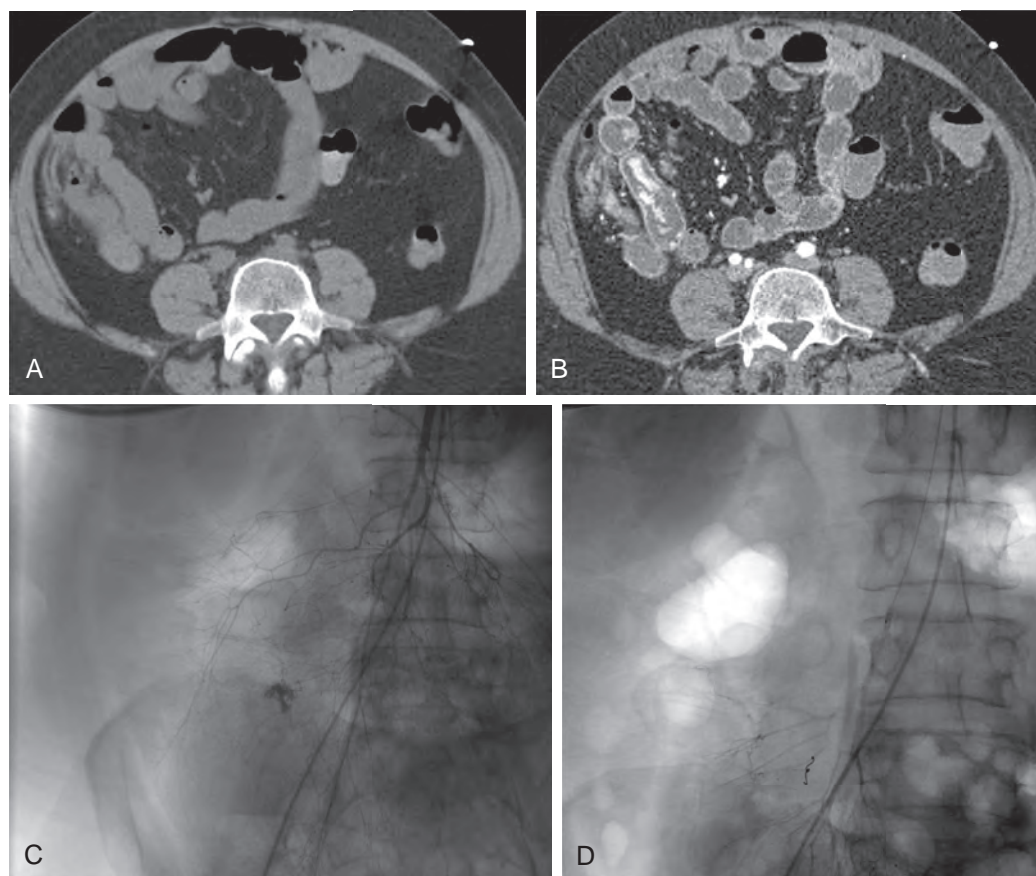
CT angiography in a patient with recent gastrointestinal hemorrhage and normal colonoscopy.
